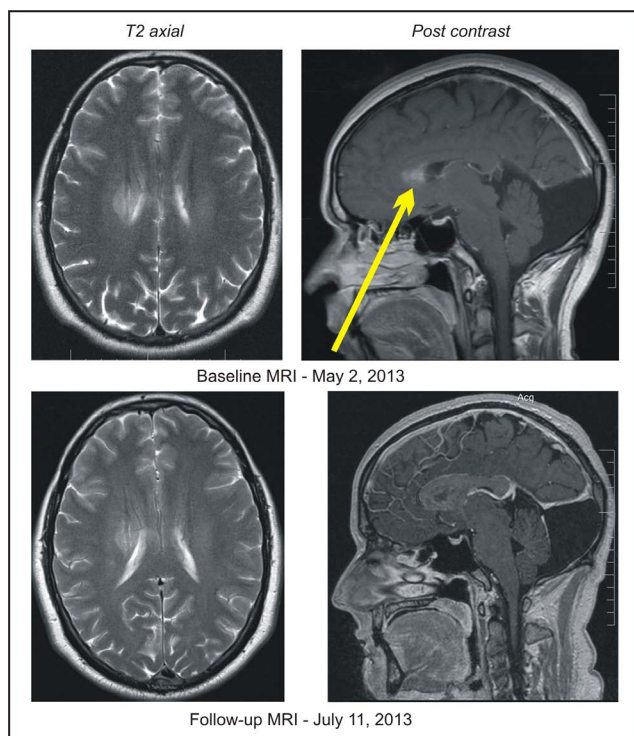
Patient 5, baseline and follow-up MRI of the head indicating partial response.
